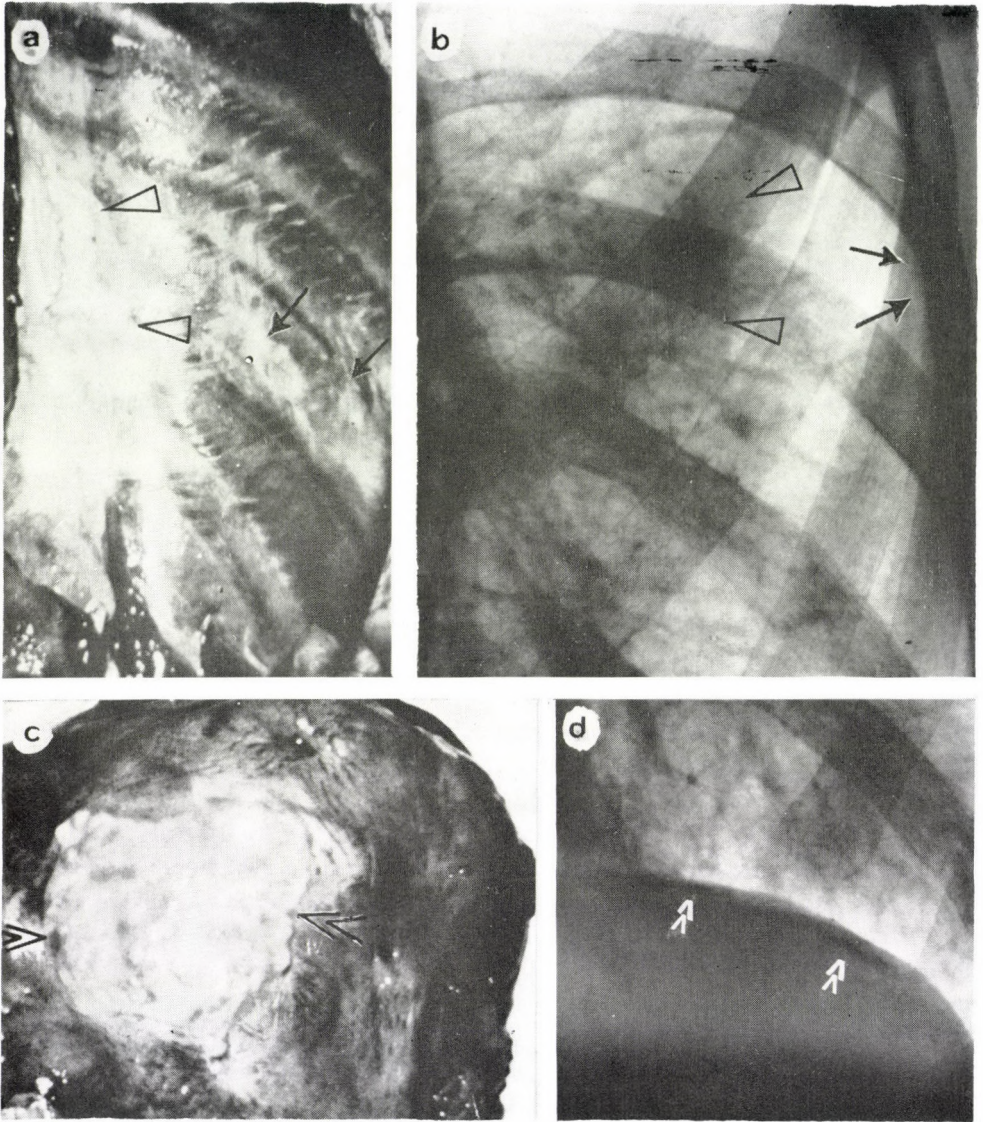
a—b—c—d Pleural hyalinosis displaying a shining yellowish-white elevation with sharp borders (Fig. 1a) best shown tangentially with oblique X-rays (Fig. 1b). Diaphragmatic surface exhibits bulky, circumscribed, disklike plaques (Fig. 1c) but in the X-rays irregular areas of calcification can only be seen (Fig. 1d \blacktriangle arrows). (ILO 1980 Geneva Short Classification: s1 a2—s1 a2)
